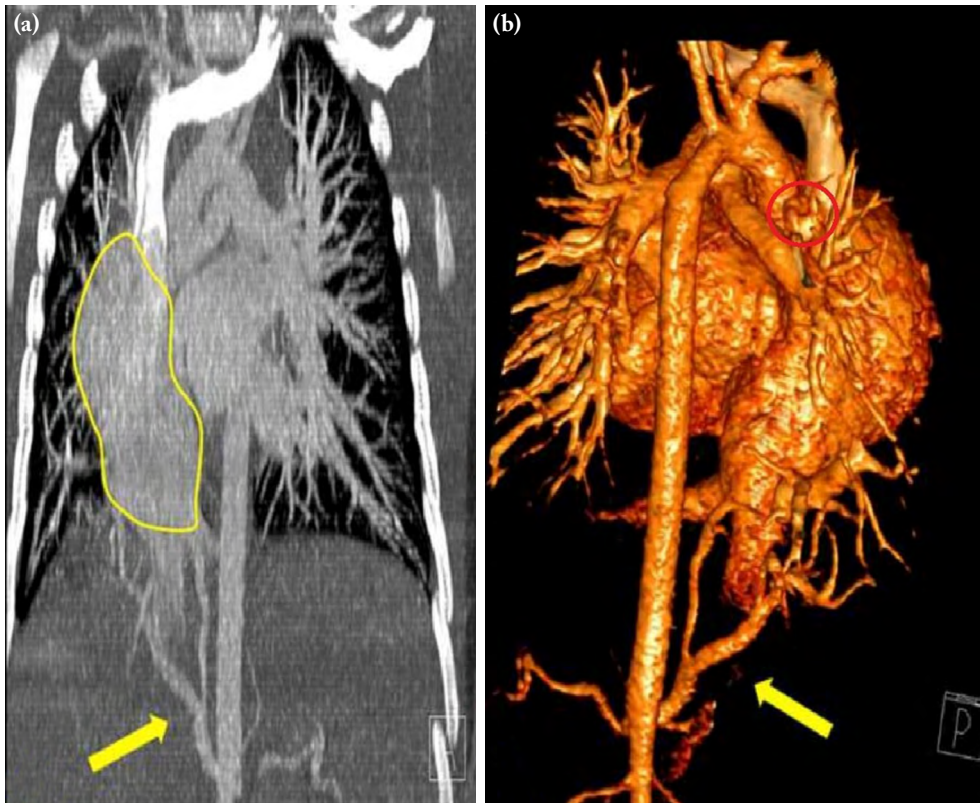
(a) Computed tomography image showing sequestered pulmonary segment. Arterial branches originating from celiac trunk were marked with yellow arrow. (b) Three-dimensional image: Arterial branches originating from celiac trunk were marked with yellow arrow and abnormal venous connection was circled.
